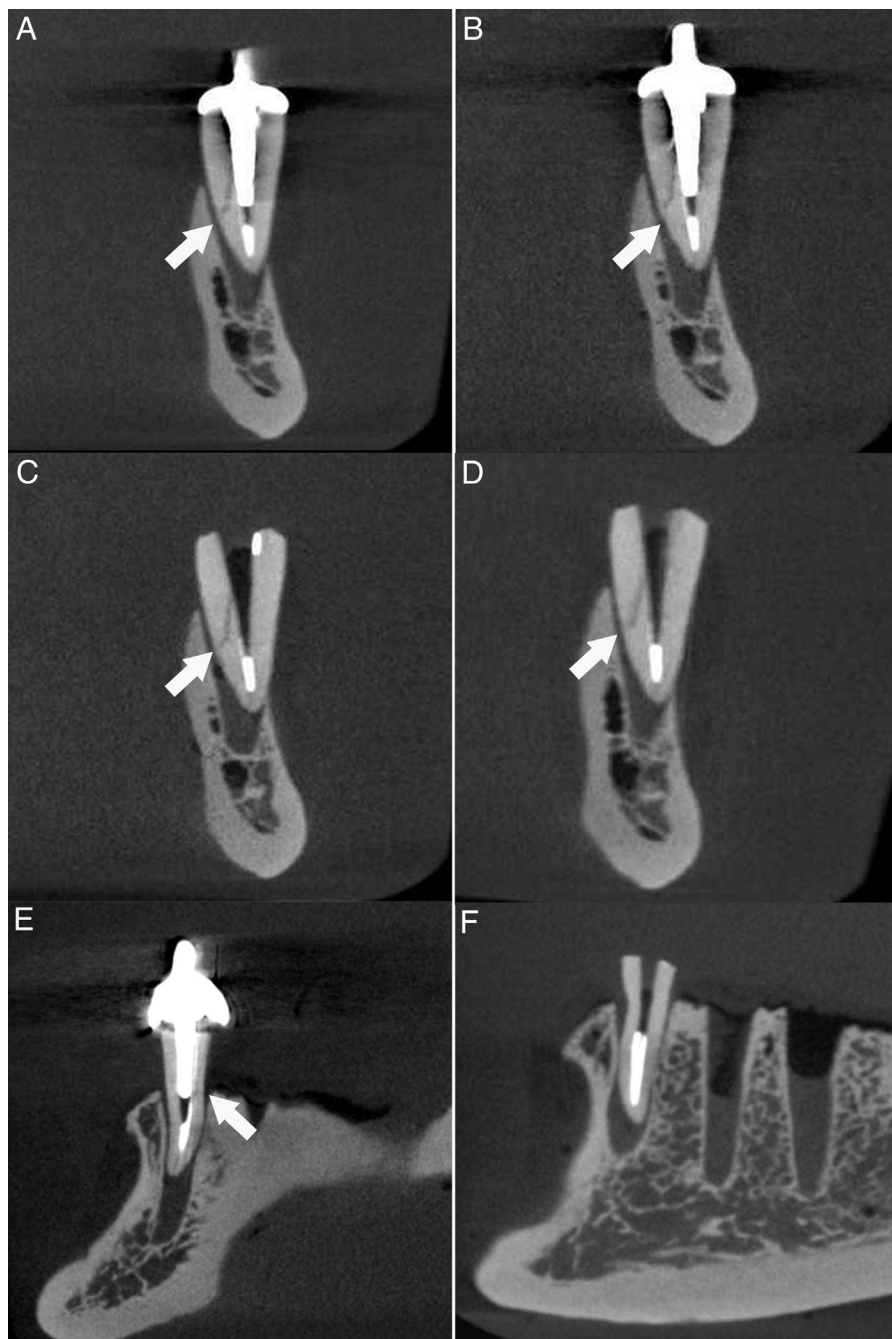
Circumferential CBCT images. (A and B) A sample with a horizontal root fracture and a metallic post (*arrow*). (C and D) A sample with a horizontal root fracture without a metallic post (*arrow*). (E) A sample without a horizontal root fracture with a radiolucent image caused by a metallic artifact (*arrow*). (F) A sample without a horizontal root fracture and a metallic post.
